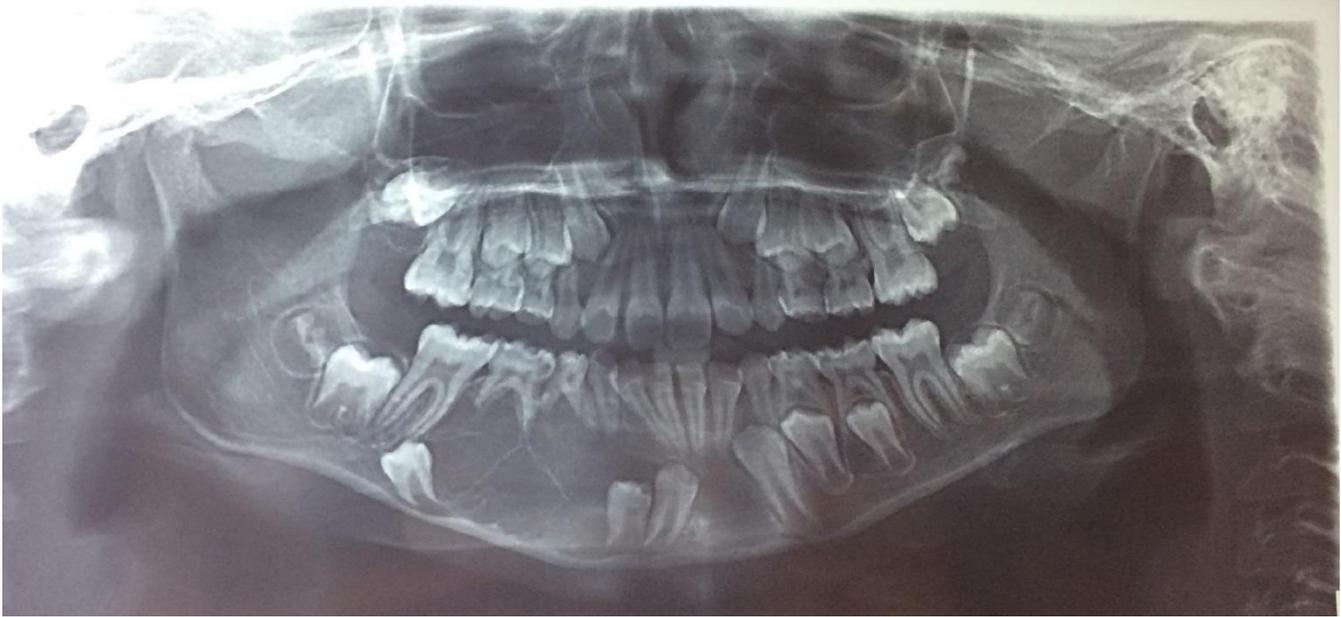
Orthopantomogram. Shows a multilocular, radiolucent lesion with fine septae in the right body of mandible
